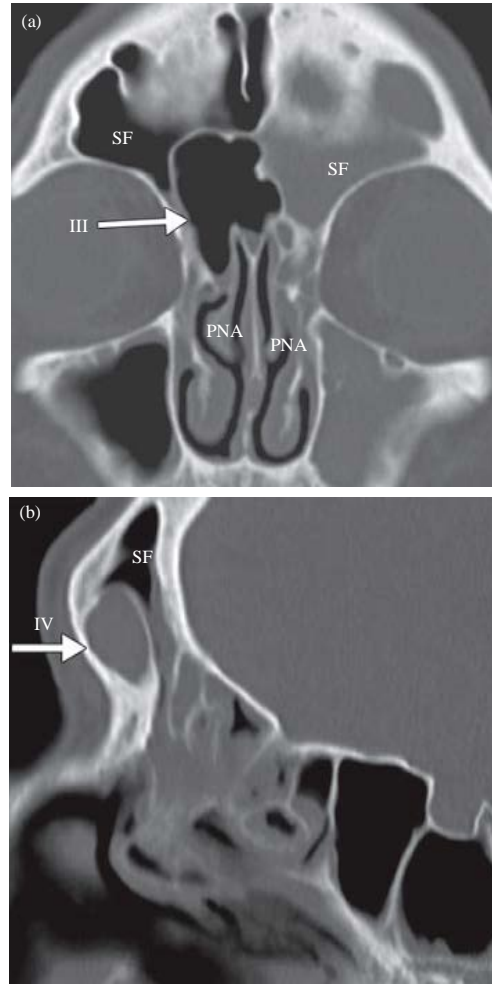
Structural variants of bulla frontalis growing into the frontal sinus: a) (coronal plane) pneumatized bulla frontalis of a trellised labyrinth, growing into the frontal sinus and blocking the fronto-nasal duct from the right side; b) (axial plane) a large isolated bulla in the frontal sinus on the left side. Diagnostic variant of a mucocele. Computed tomography of the paranasal sinuses. Nomenclature (PNA): Parisiana Nomina Anatomica, SF: a frontal sinus an arrow shows the variant of bulla frontalis
